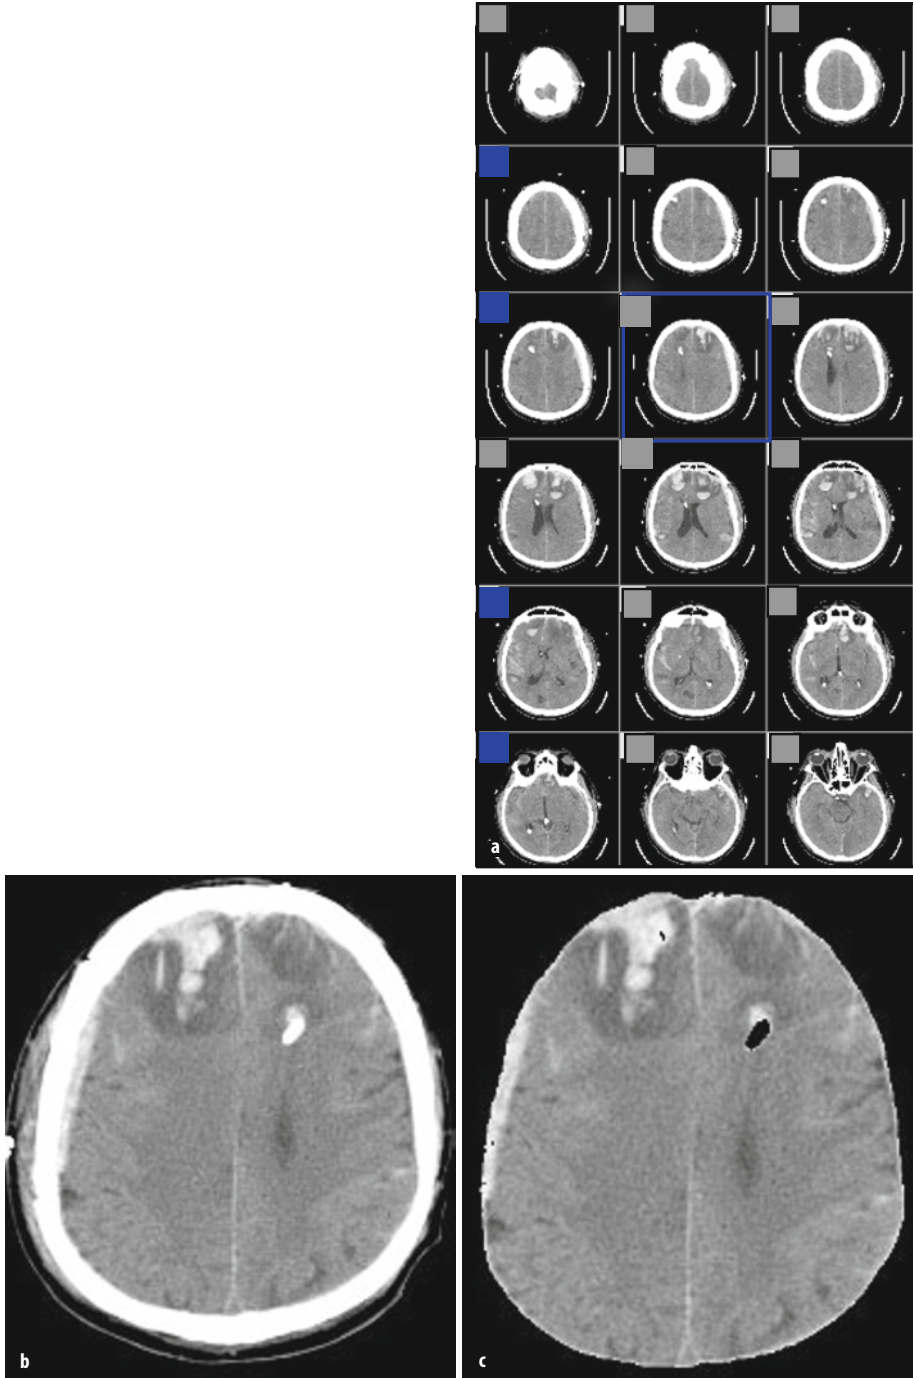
BrainView software working window. CT DICOM image imports (a, b); automatic exclusion of extracranial compartments (c).
